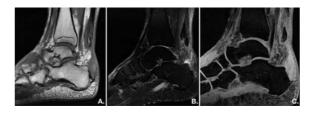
Sagittal T1-weighted (A), T2-weighted (B), and STIR MR (C) images showing a bony fragment approximately 1.0x0.8 cm at the distal part of the Achilles tendon which had been avulsed from the calcaneal tuberosity.
